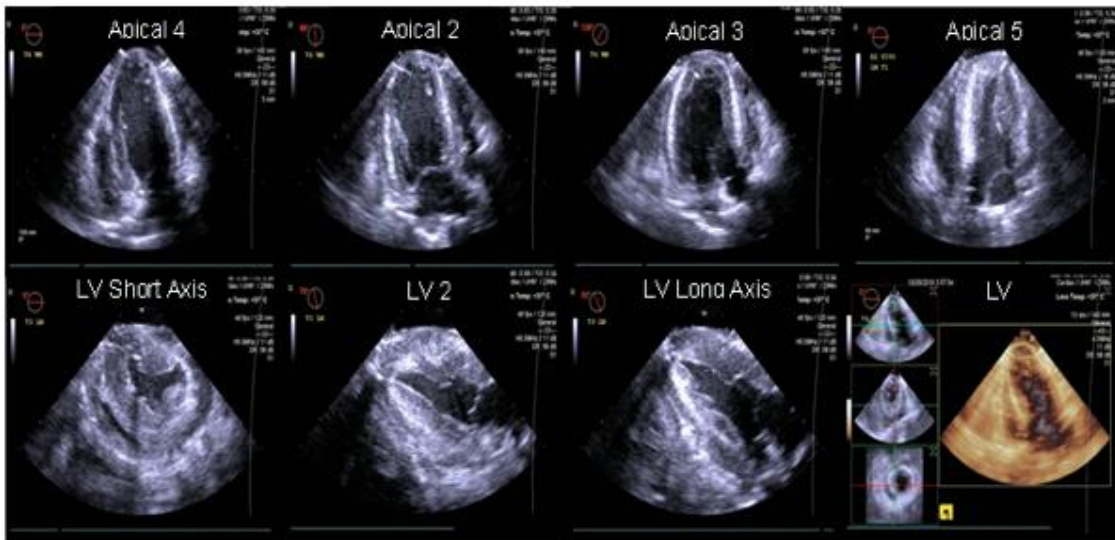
Modified epicardial echocardiography views acquired with a 3 D custom made setup
